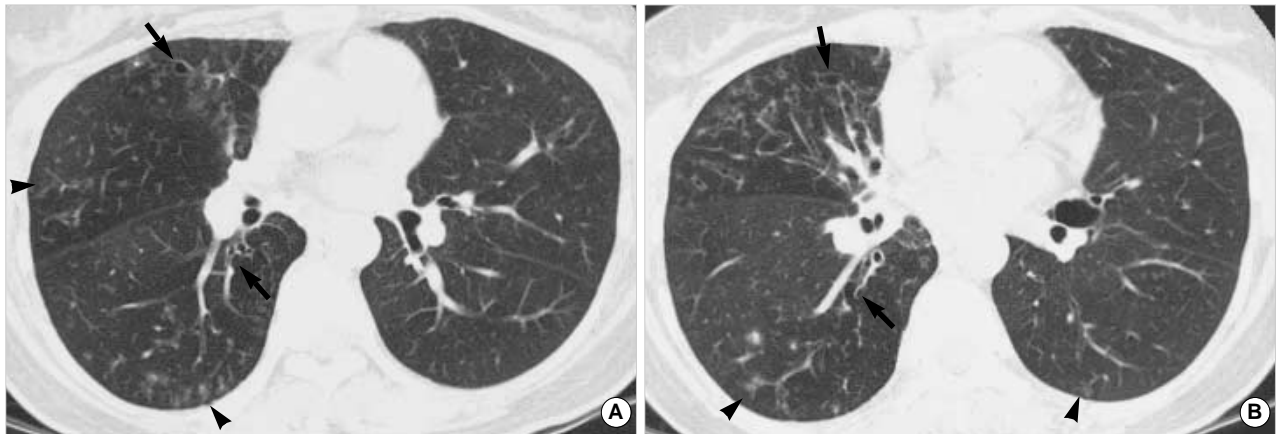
A 45-yr-old woman with *M. abscessus* pulmonary disease. (A) Transaxial thin-section (2.5-mm thickness) CT scan obtained at level of proximal lower lobar bronchus shows bronchiectasis (arrows) and multiple small nodules and branching centrilobular nodules, so-called tree-in-bud pattern (arrowheads) in right lung. (B) CT (2.5-mm thickness) scan obtained at level of basal trunk shows bronchiectasis (arrows) and multiple small nodules and branching centrilobular nodules, so-called tree-in-bud pattern (arrowheads) in both lungs.
